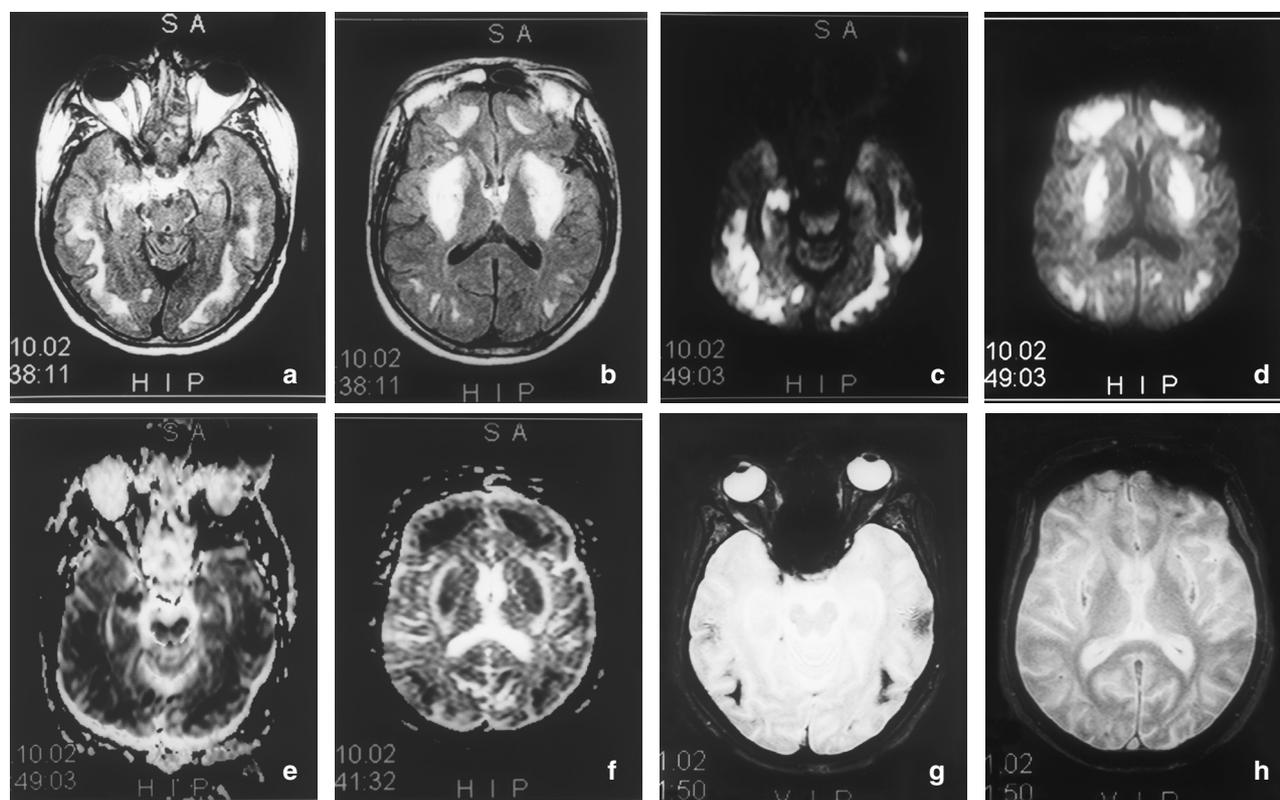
a–h). Case 2. a, b) Initial axial FLAIR MRI shows bilateral symmetric high signal intensity areas involving the posterior temporal, occipital, frontal and parietal subcortical white matter. Note abnormal signal intensity within the basal ganglia and also the right hippocampus. c, d) Axial DW images ( $b$ -value  $1000 \text{ s/mm}^2$ ), c) at a lower level and d) at a higher level, demonstrate high signal intensity and e, f) low ADC in the subcortical white matter, basal ganglia, and right hippocampus, as can be seen in cytotoxic edema. g, h) Axial T2-weighted gradient-echo images at 3 weeks show low signal foci in the putamina and subcortical white matter, predominantly within occipital lobes, representing focal hemorrhage.
